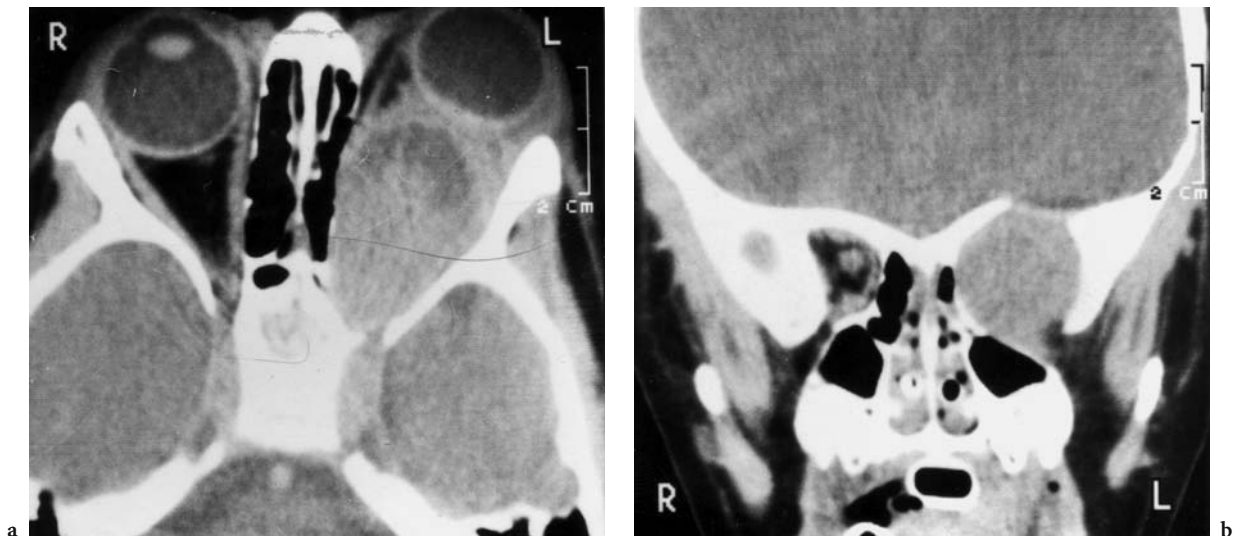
A 2-year-old girl with proptosis of the left eye. Diagnosis: left optic nerve glioma. CT: a Wide, sharply defined tumor occupying the entire orbit. Enlarged orbital diameter with depression of the left lamina papyracea and left lateral orbital wall (compared with right side), indicating slow tumor growth. b Coronal view showing the large diameter of the orbital apex and optic canal. The defect of the orbital roof is due to a previous operation. (With permission of MÜLLER-FORELL and LIEB 1995b)
